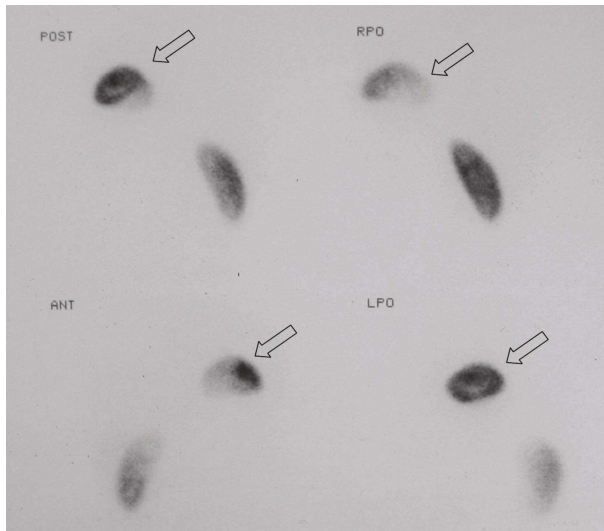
Tc-99m DMSA scintigraphy shows normal radiotracer uptake with smooth contours of the left intrathoracic kidney.
